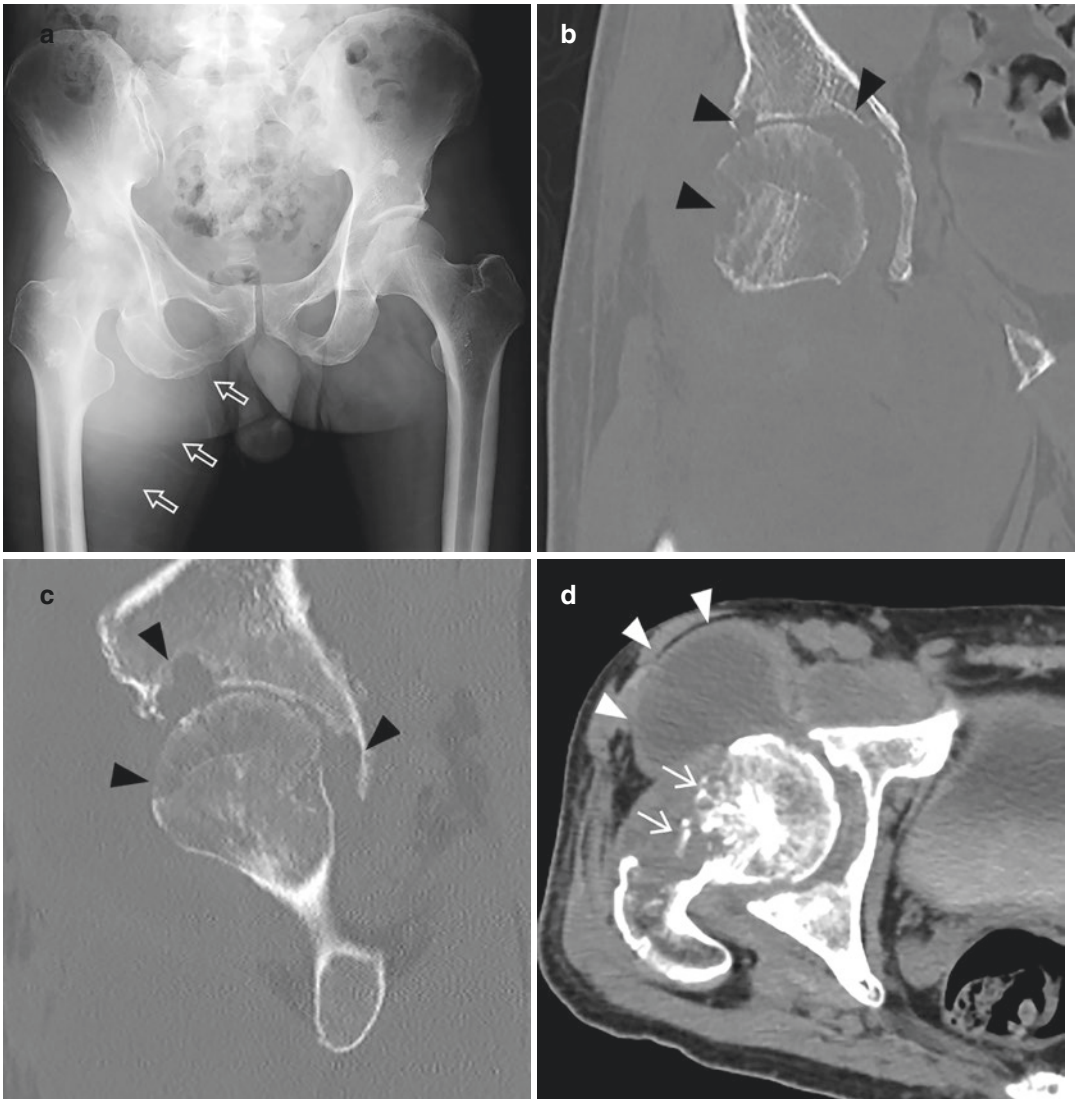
Tuberculous arthritis in a 54-year-old man who had right hip pain and a groin mass for 4 months. (a) Frontal radiograph shows right hip joint destruction and juxta-articular osteoporosis. Note the large soft tissue shadow in the right upper thigh (open arrows). (b) Coronal
